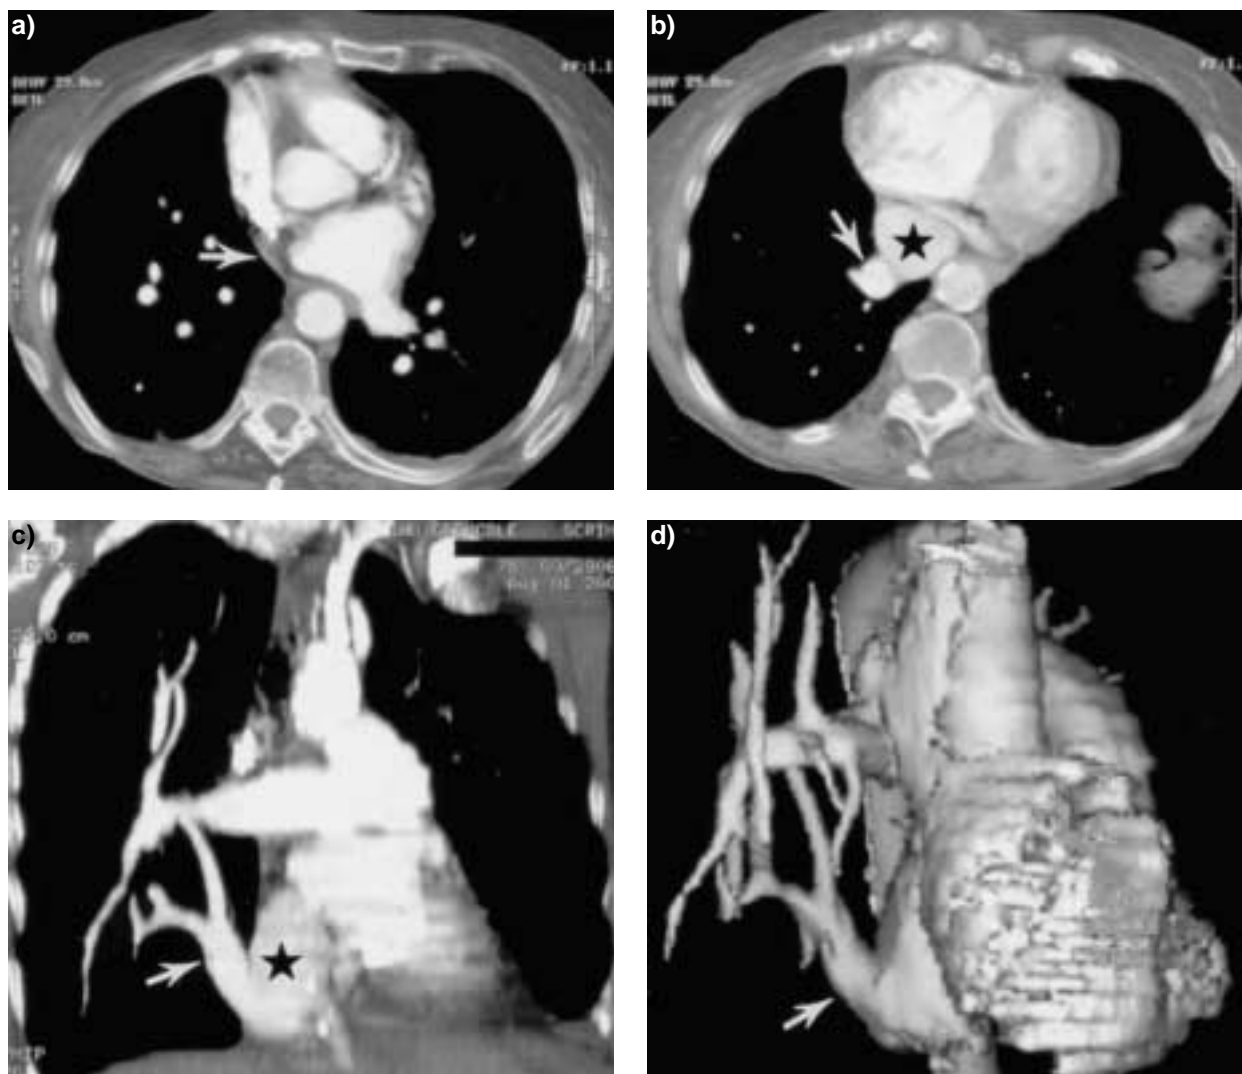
A 78-yr-old female with history of chronic dyspnoea and scimitar syndrome. Contrast enhanced computed tomography (CT) was acquired with 3-mm sections. a) Axial CT image at the level of the left atrium shows absence of left upper pulmonary vein (arrow). b) Axial CT image at the level of the right inferior pulmonary vein (arrow) shows enlargement of the vein that enters the right atrium (star). c) Coronal multiplanar reformation shows the enlargement and abnormal position of the right pulmonary vein (arrow) and the continuity with the right atrium (star). d) Three-dimensional surface shaded display view in a coronal projection of the malformation (arrow).
